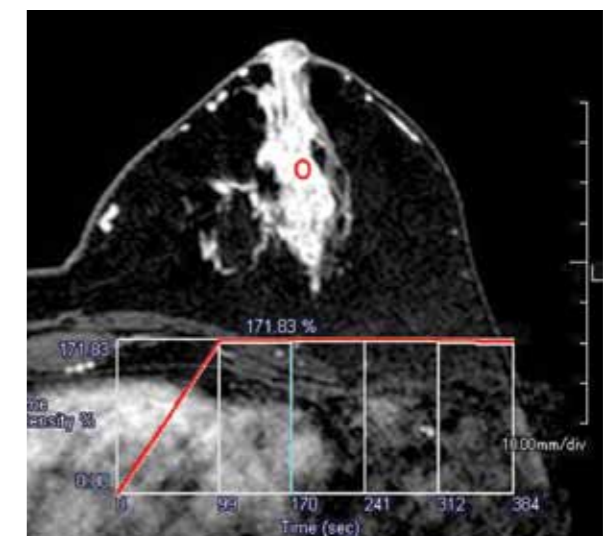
Kinetic analysis of contrast material uptake on MRI in Grade 3 DCIS: graph plotting degree of enhancement vs time shows rapid initial uptake and a prolonged plateau of enhancement
